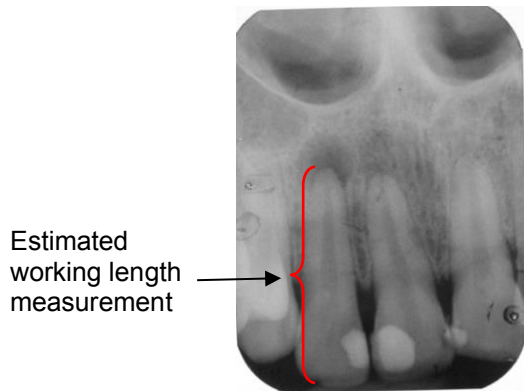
Measurement of estimated working length from a pre-operative radiograph
